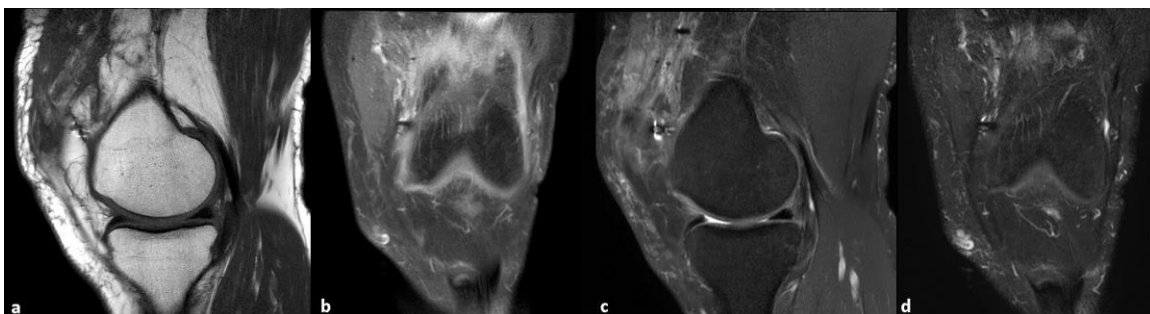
In postoperative fat-suppressed T1-weighted sagittal image (a), fat-suppressed postcontrast T1 weighted coronal image (b), fat-suppressed proton density sagittal image (c), and fat-suppressed T2-weighted coronal image (d), postoperative changes are seen. Residual tumor was not seen.
